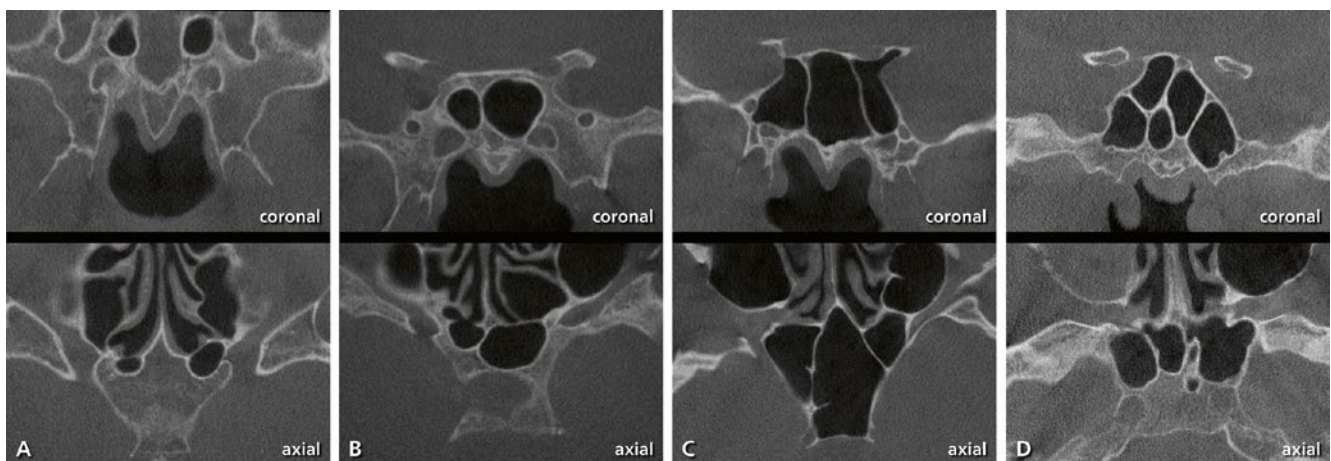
CBCT sections of varying number and appearance of septa in four different patients (coronal and axial views): A = two separate chambers with no septum; B = one septum; C = two septa; D = multiple septa
